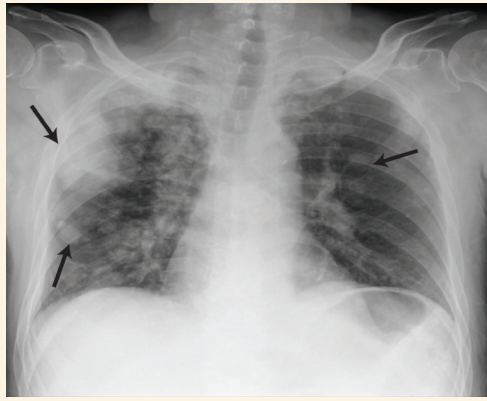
Coronal chest X-ray of a 58-year-old male patient (case two) showing bilateral pulmonary nodules and masses (black arrows), predominantly in the right lung.
